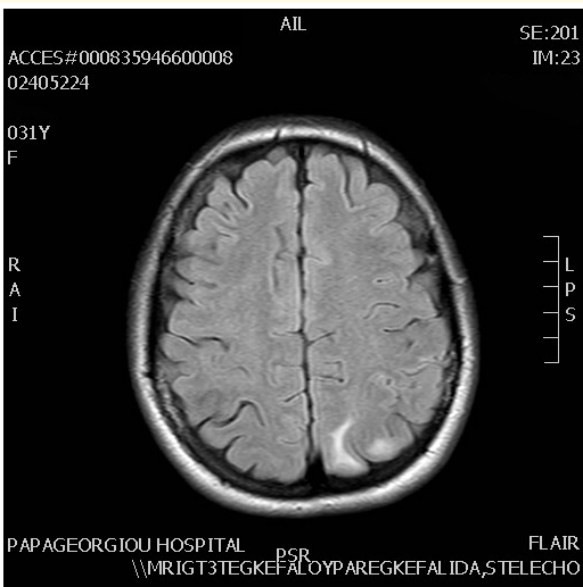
Magnetic resonance imaging with T2-flair-weighted images showing lesser hyperintense lesions in the occipital lobes indicating the presence of vasogenic oedema.
